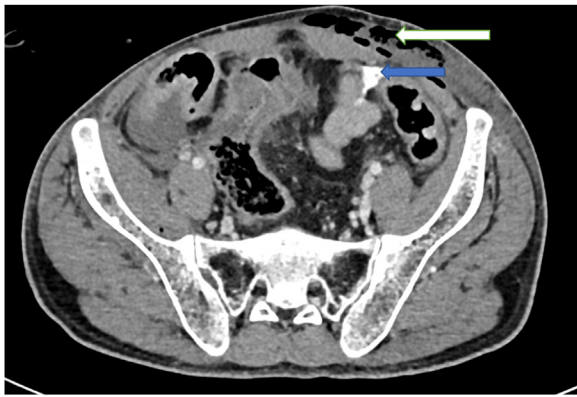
CE CT Abdomen with blue arrowhead showing leak of contrast from the small bowel lumen and White arrowhead showing air in the subcutaneous tissue.
